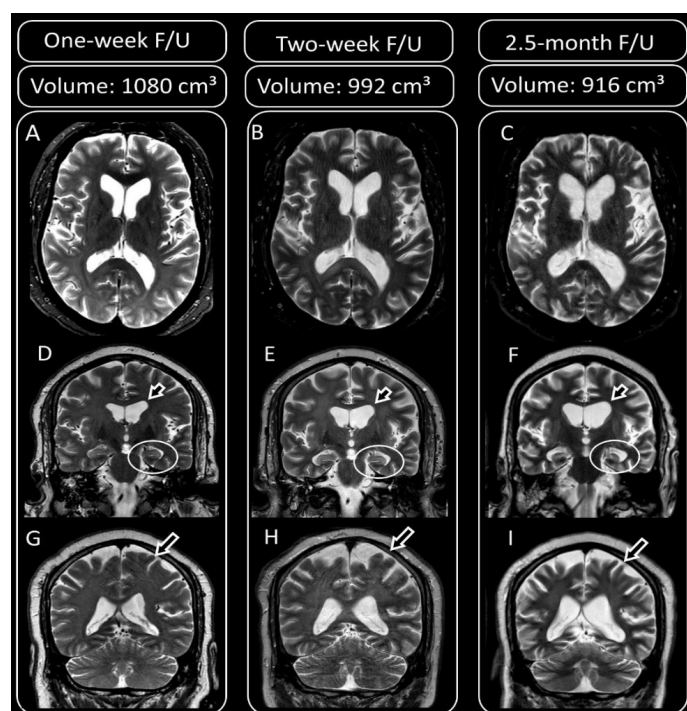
Comparison among three different MRI scans; axial T2-weighted images (A, B, and C), coronal T2-weighted images at the level of hippocampi (D, E, and F), and coronal T2-weighted images more posterior at the level of cerebellum (G, H, and I) show increasing prominence of lateral ventricle and the cerebral sulci during the time which is consistent with generalized cerebral atrophy.
